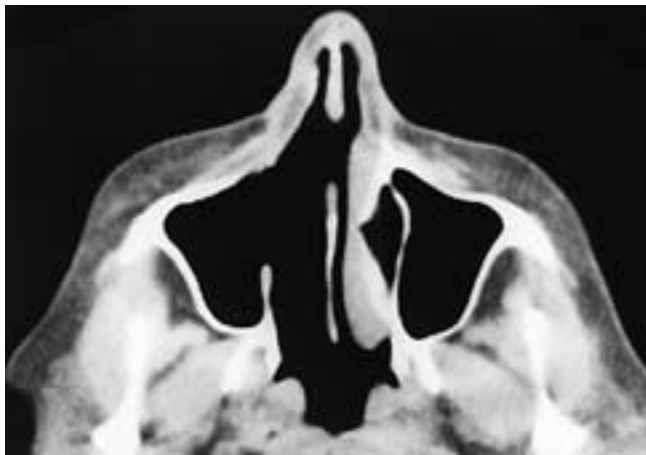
Axial CT scan shows the normal appearance after partial right maxillectomy. The medial antral wall has been removed, and the soft tissues in and around the antrum should be smooth.
